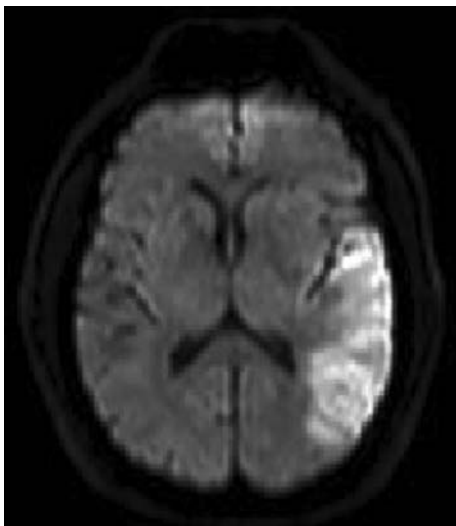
MRI scan, diffusion weighted image, showing an acute stroke in the left temporal lobe, resulting in Wernicke's aphasia.
